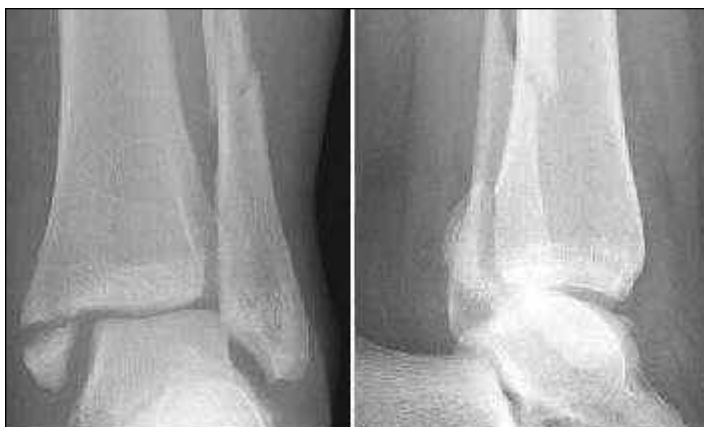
Anteroposterior and lateral radiographs showing a displaced trimalleolar fracture.
